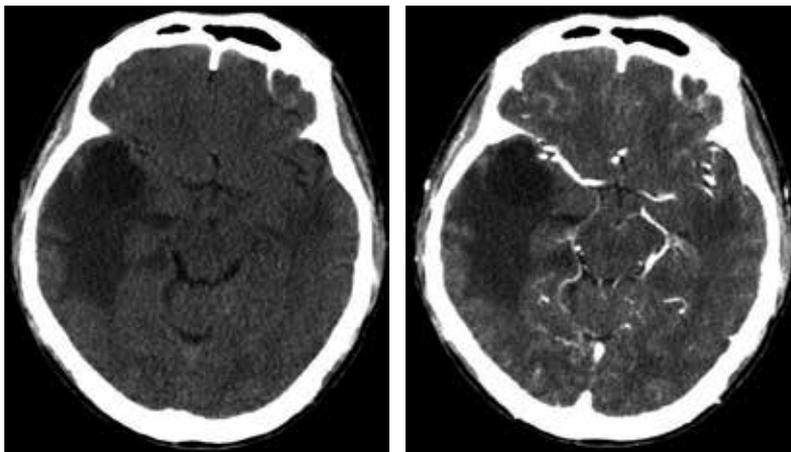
CT founding of a 59-year-old male patient with NPC after radiotherapy for over 10 years. A. cystic liquefactive necrosis of the right temporal lobe with edema around lesions. B. no enhancement.
